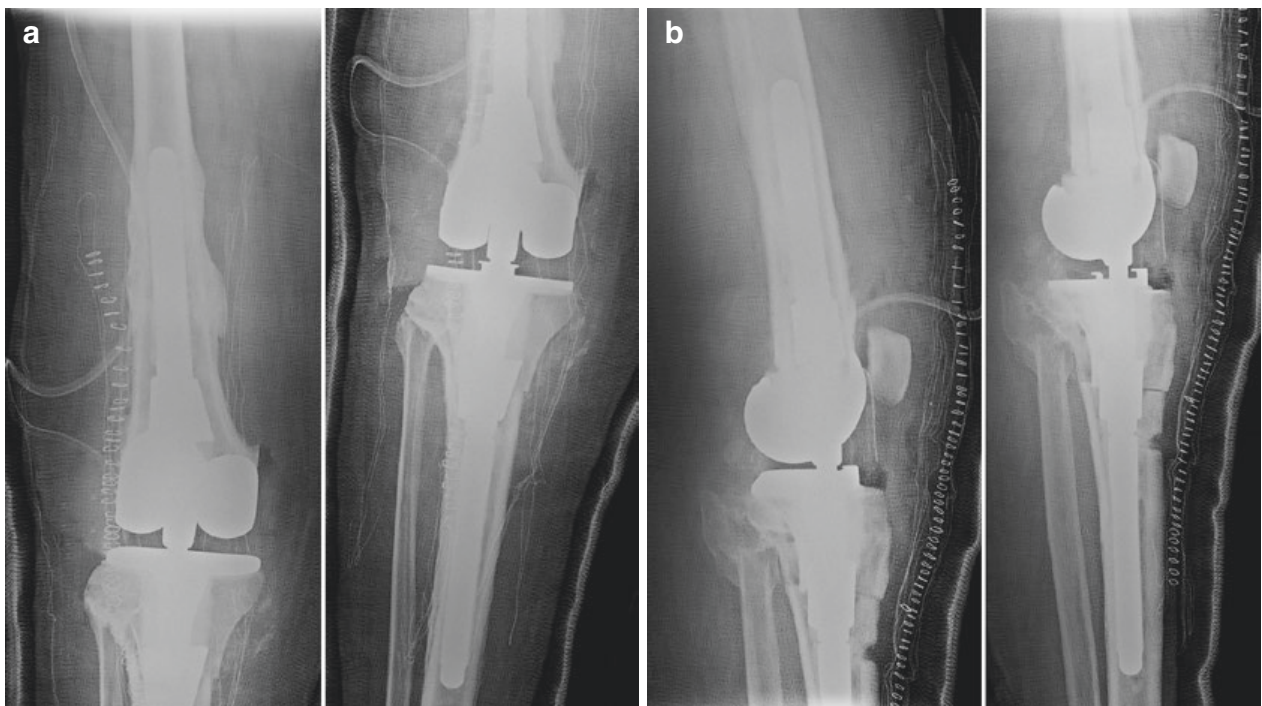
(a, b) Postoperative x-rays of the patient
